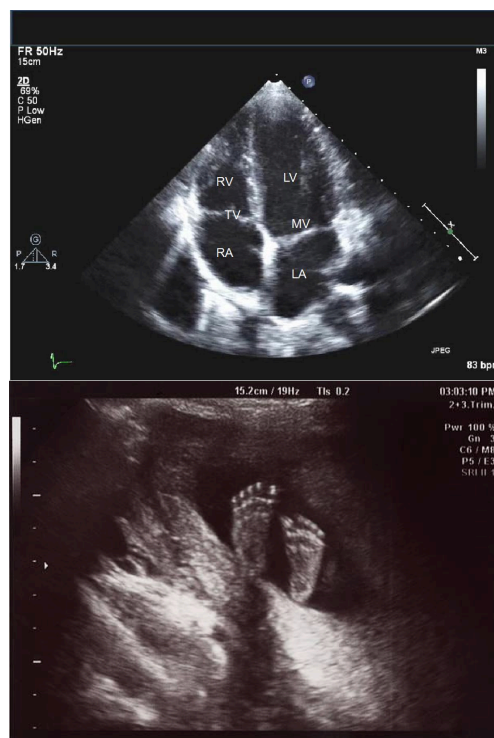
Example of sonogram.
